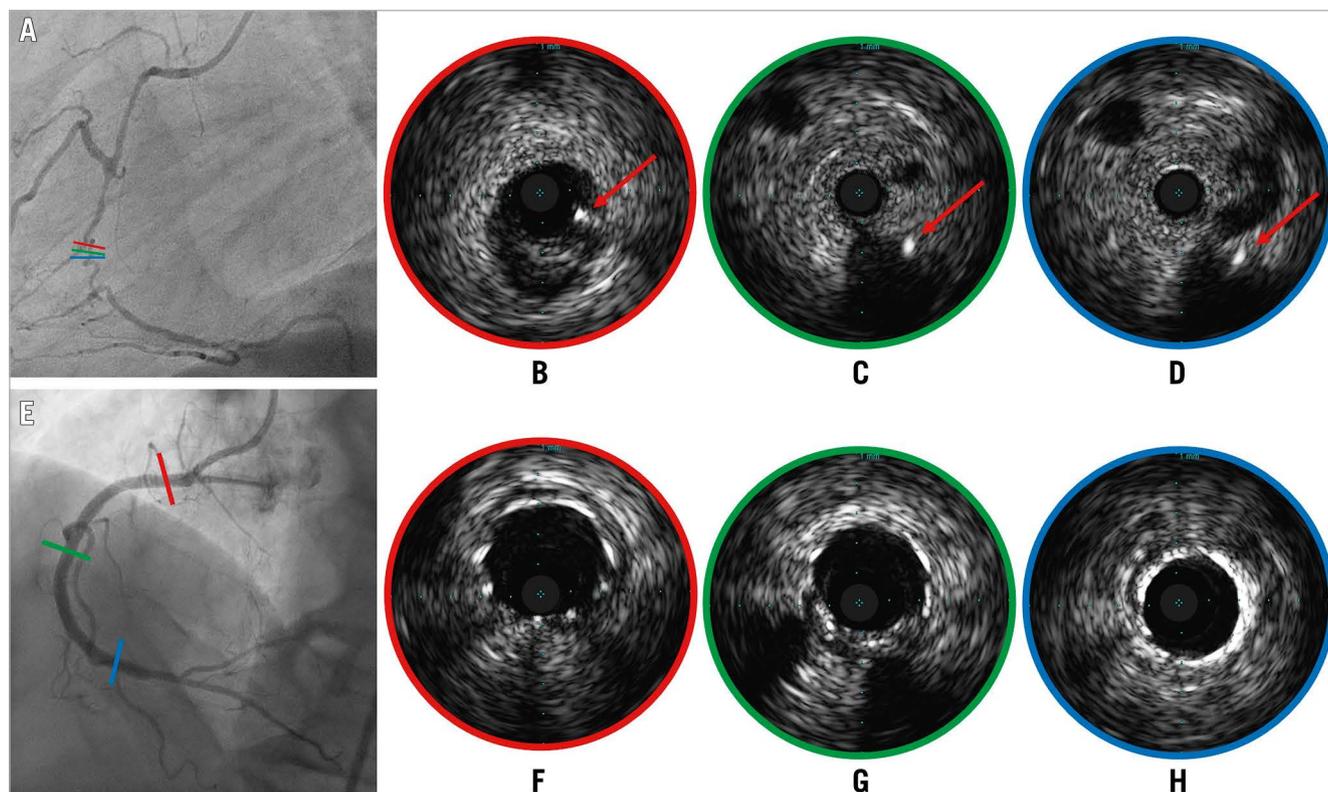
IVUS-guided puncture of an angiographically ambiguous proximal CTO cap. A) Blunt occlusion of the mid-RCA. A right ventricular branch allows insertion of an IVUS probe with its piezoelectric crystal positioned at the CTO ostium; coloured lines indicate the position of IVUS cross-sections. B - D) A Gaia third guidewire (Asahi Intecc) (red arrows) punctures, under IVUS guidance, the proximal (B), the mid (C) and the distal (D) segment of the CTO. E) Final angiographic result after deployment and expansion of multiple stents from the third segment to the ostium guided by repeated IVUS runs; coloured lines indicate the position of IVUS cross-sections confirming optimal expansion (F - H, respectively, from proximal to distal segment). CTO: chronic total occlusion; IVUS: intravascular ultrasound; RCA: right coronary artery
